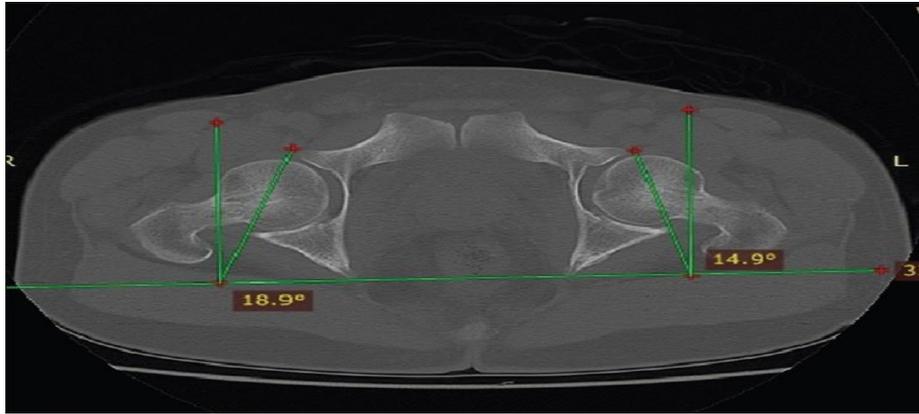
CT scan axial cut pelvis showing acetabular version.
